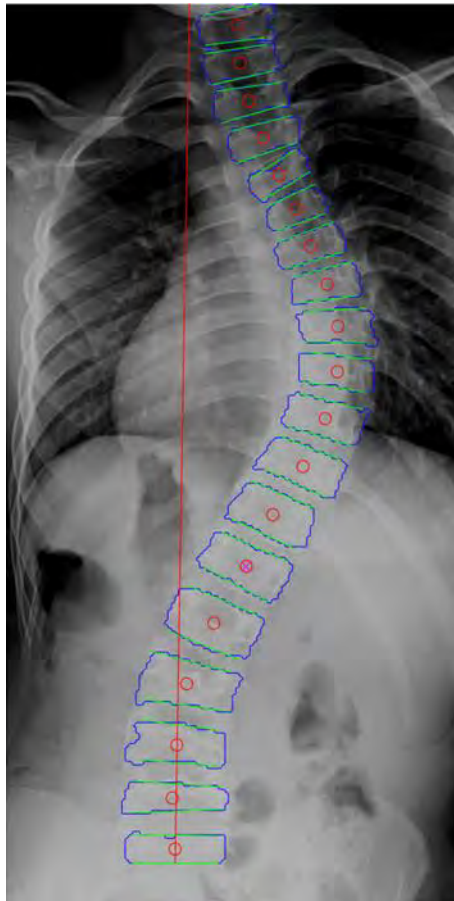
AI model output of X-ray image, with RCS-specific parameters visualized
